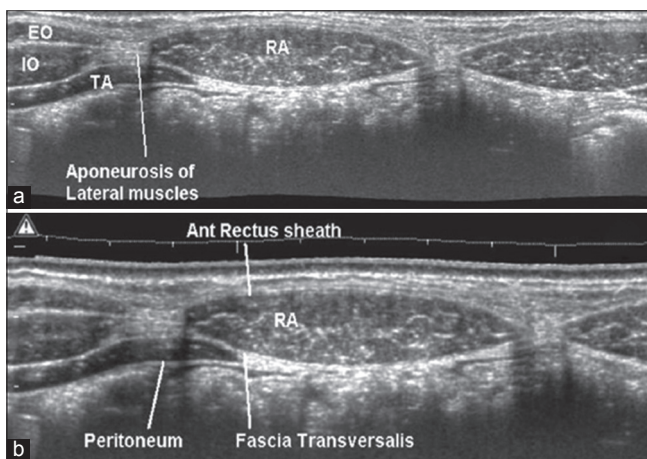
(a and b) Transverse sonography of the anterior abdominal wall. RA: Rectus abdominis, TA: Transverse abdominis, EO: External oblique, IO: Internal oblique
